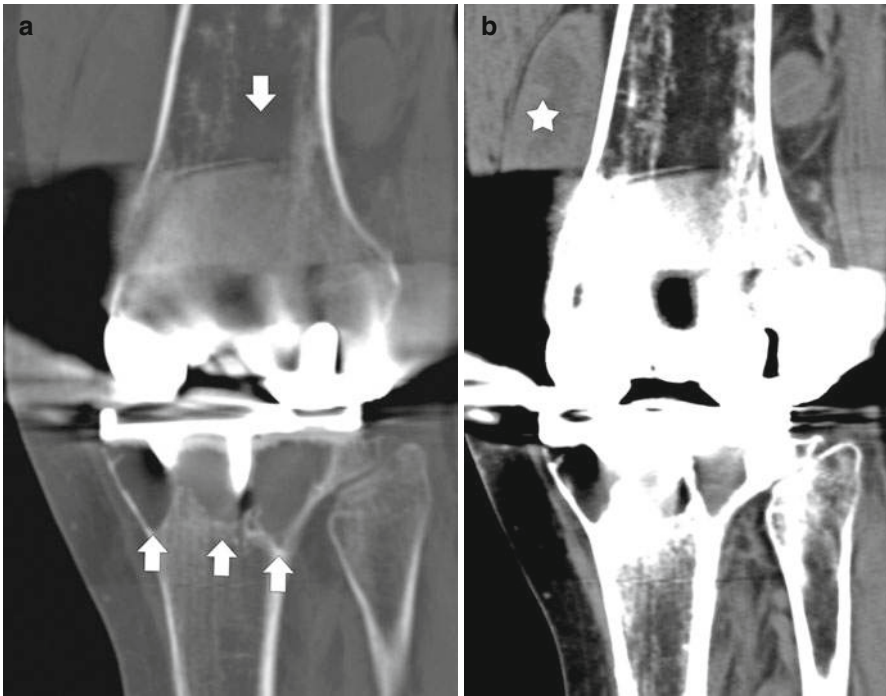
Osteolysis after knee arthroplasty. Knee CT coronal reconstruction images in bone (a) and soft tissue (b) windows reveal lucency in bone adjacent to hardware (*arrows*) and a complex joint effusion (*star*) suggesting severe synovitis
